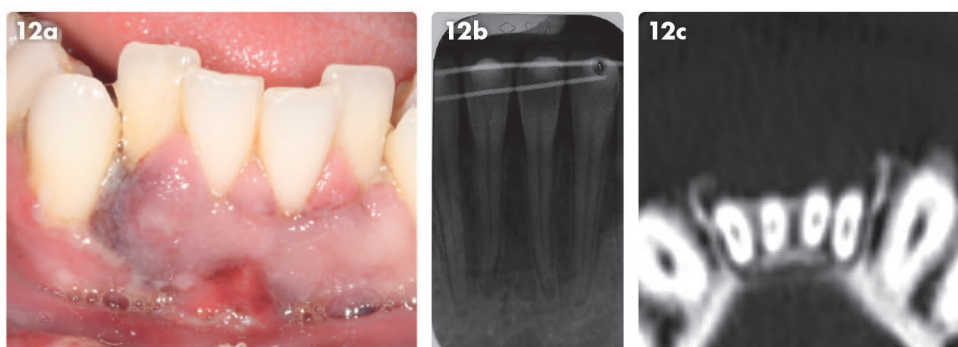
(a) Dentoalveolar fracture that includes all four mandibular incisors. Note the soft tissue tear and that all four incisors moved in unison; (b) A mandibular occlusal radiograph of the incisors shows a faint radiolucent horizontal line in the apical third of the roots; (c) A coronal slice of a CBCT shows that the buccal and lingual cortical plate around the mandibular incisors is fractured
